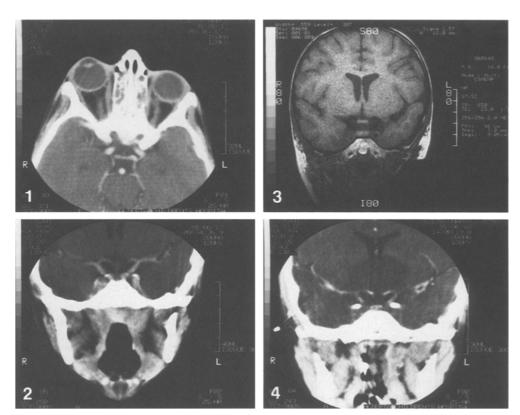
Enhanced axial CT of the orbits demonstrates right proptosis without evidence of preseptal edema or orbital fat infiltration. The right medial rectus muscle is thickened and slightly laterally displaced. Ethmoid air cells are opacified
